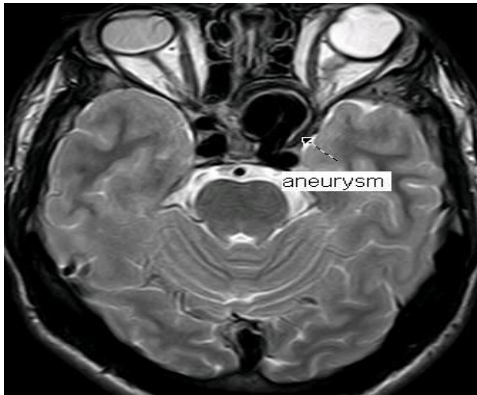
(c) Aneurysm in MRI
